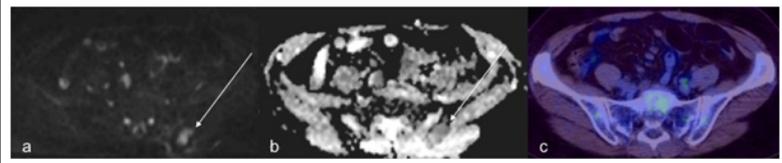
A 65-Year-Old Female Patient with DLBCL, a Focus of Restricted Diffusion (a,b) in the Left Posterior Ilium (thin arrow) was found to be False Positive with no Increased Uptake Detected on PET/CT (c).
